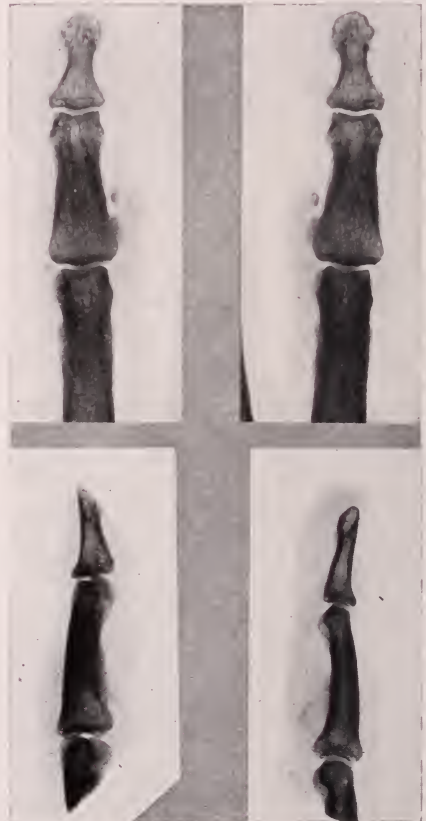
Case 1. X-ray of finger showing a pedicle of bone (exostosis) with new bone formation in body of tumor.
